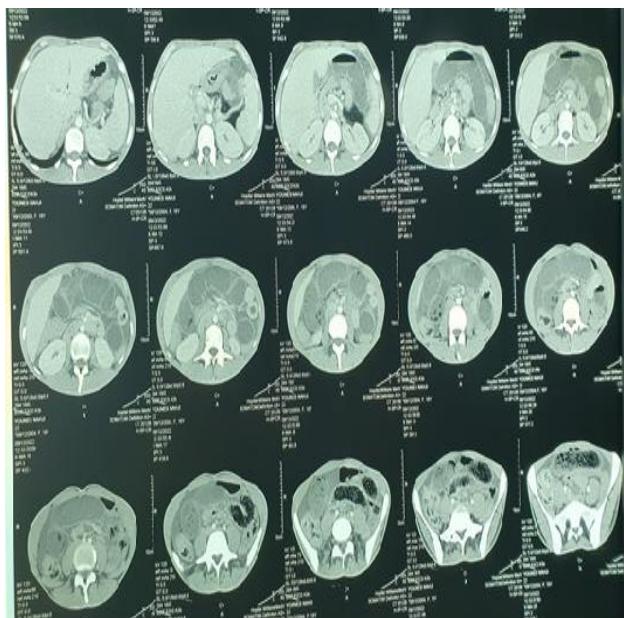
CT scan picture shows dilated small bowel and air fluid levels, fesses sign.
